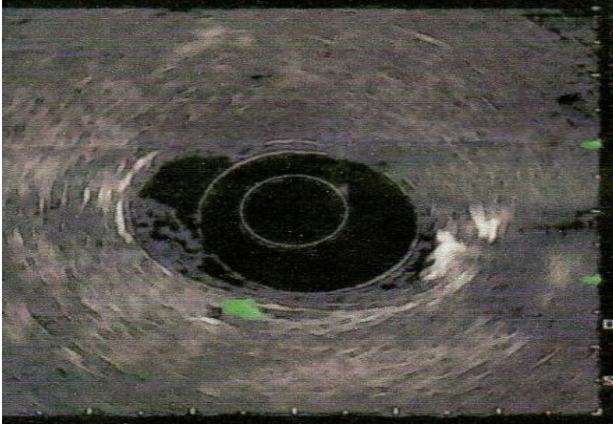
2 Endoscopic ultrasound showing duodenal carcinoid.
